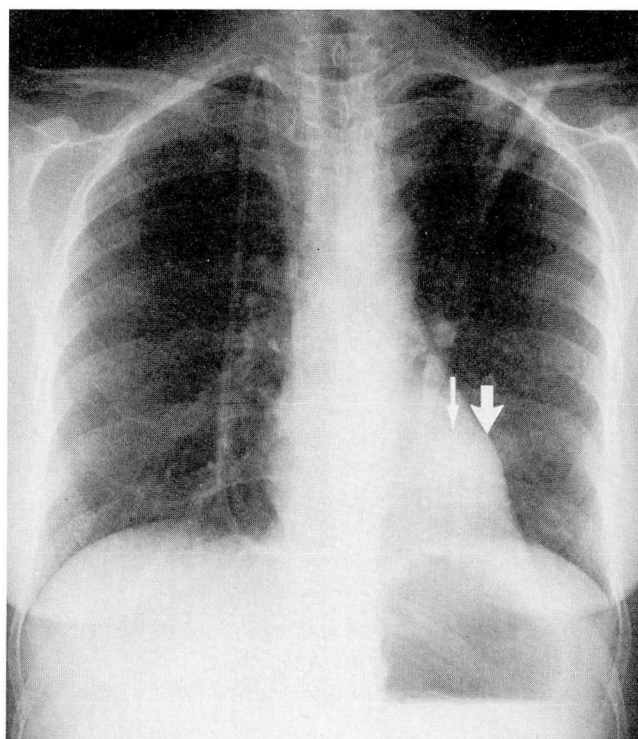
Chest radiograph reveals two ill-defined left lower lung nodules. The more medial nodule was present 1 week earlier (thin arrow). A second nodule (thick arrow) developed subsequently. A right Hickman catheter is in place.
